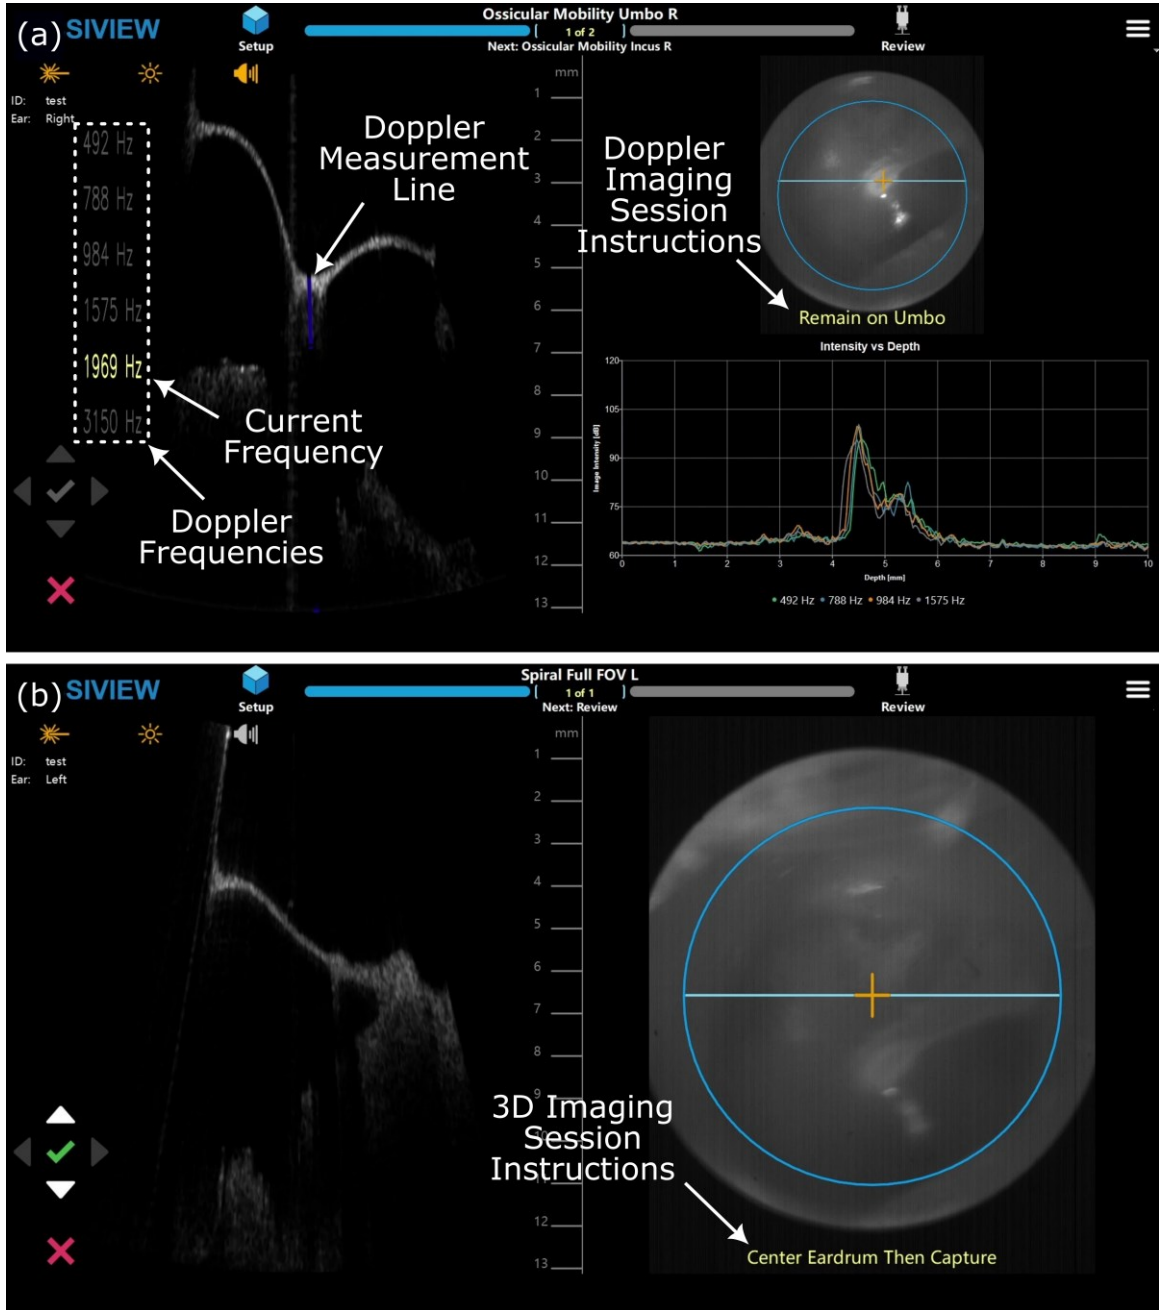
Report component driven workflow for (a) Doppler imaging session and (b) 3D imaging session.
